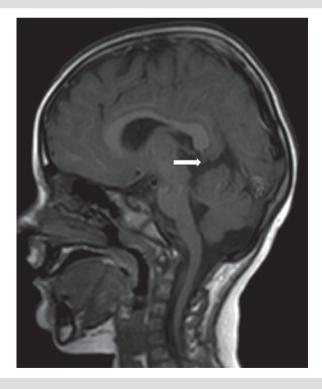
In the sagittal TI-weighted MR image of the same patient as Figure 1, the herniated cuneuate gyrus extends towards the superior cerebellar cistern (white arrow)
